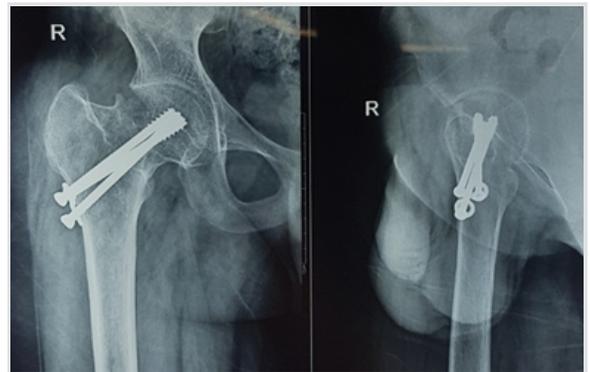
Ten months follow-up radiographs.
